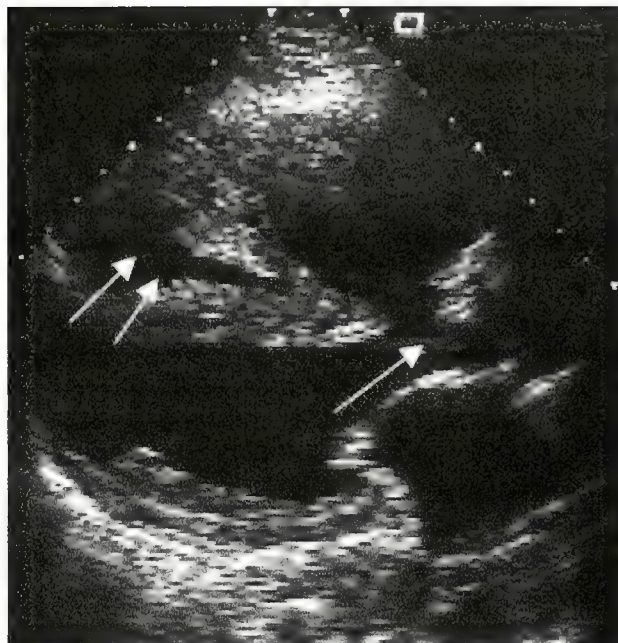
Two-dimensional echocardiogram (parasternal long axis view) demonstrating a large ventricular septal defect and over-riding aorta (single arrow), and a dilated RV with a thickened RV wall (paired arrows).
